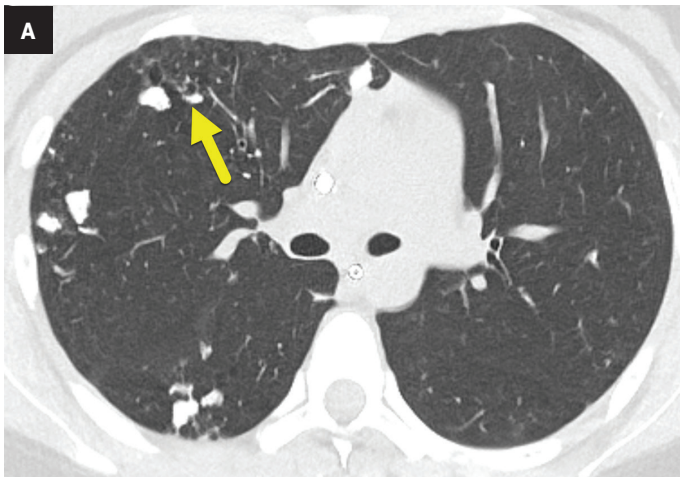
(A) Axial and (B) coronal noncontrast chest CT performed 18 months after that presented in Figure 1 shows a substantial post-treatment decrease in MPC. However, some dense calcifications remain. Additionally, some of the lung parenchyma that was previously calcified (arrow) now has a cystic appearance.
